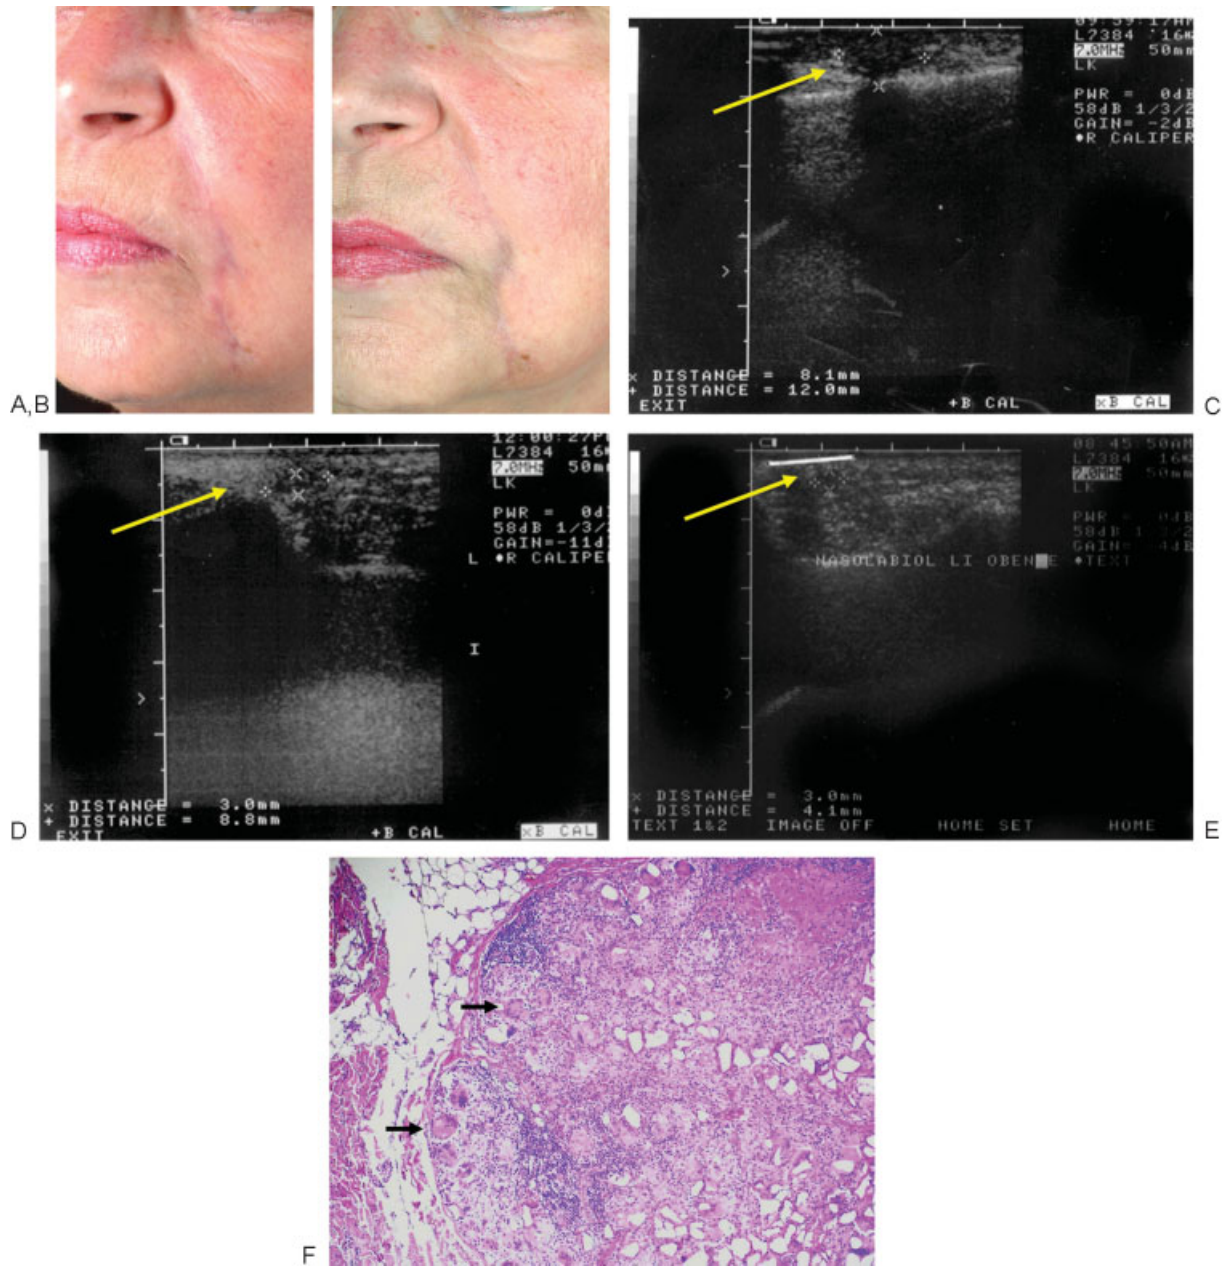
Successful treatment of a patient suffering from therapy-resistant granulomas after Dermalive injections (hydroxy-ethyl-methacrylate, ethyl-methacrylate, hyaluronic acid) into the nasolabial fold 7 years after injection. Clinical view before (A) and 6 months after therapy (B) with 5-fluorouracil (5-FU). Intralesional injections of 1 to 1.5 mL of 5-FU 250 mg/0.8 mL, supplemented with triamcinolonacetoniid 0.1 mL and scandicaine 1% 0.1 mL, according to the treatment scheme of Table 6. Sonographic checks before (C), after 7 months (D), and 9 months (E) show significant reduction of granuloma formation. Biopsy taken before treatment shows foreign-body giant cells (arrows), macrophages, and lymphatic infiltration (F).
